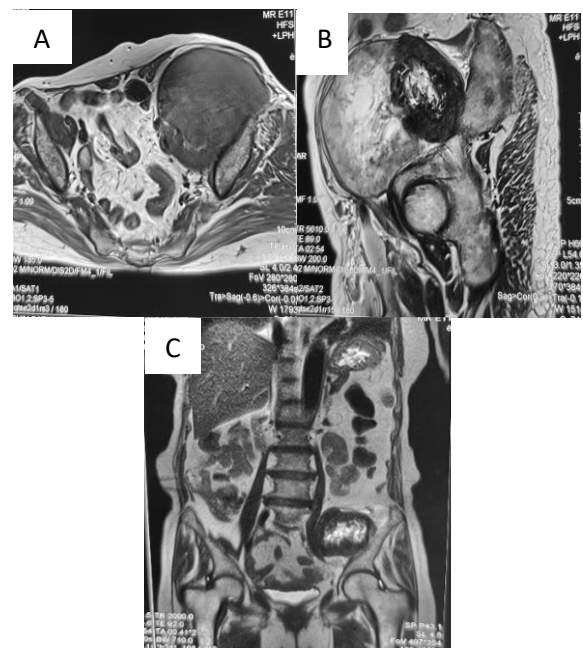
A) MRI abdomen with mass in left iliac fossa abutting left iliac blade and anterior abdominal wall, no bony involvement. B) Mass with solid and necrotic areas reaching upto left joint cavity without joint involvement. C) Sagittal section.
